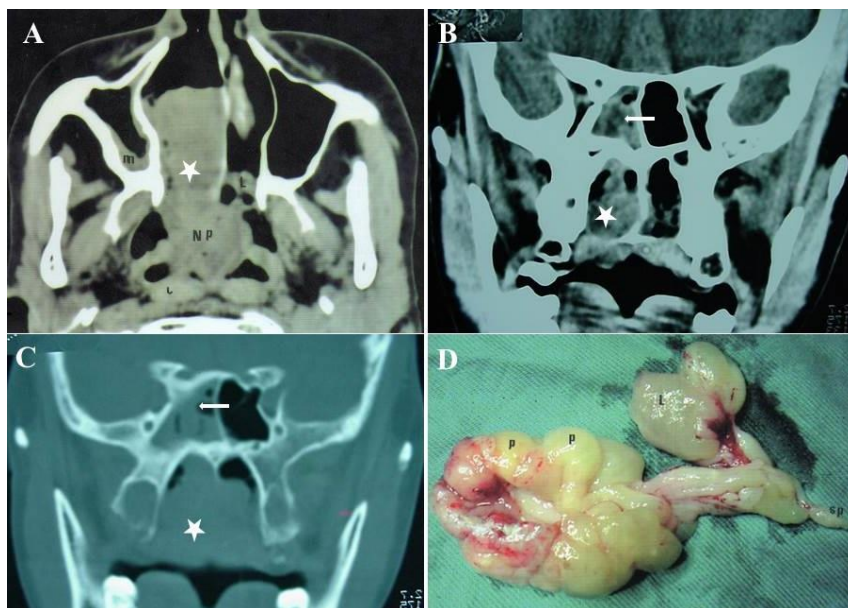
(A) CT scan with axial soft tissue window cut showing a soft tissue density mass filling most of the right nasal fossa (white asterisk), extending through the right choana into the nasopharynx (NP), then through the left choana into the posterior part of the left nasal fossa (L), with underdeveloped right maxillary sinus with concentric mucosal thickening (m). (B, C) CT scan with coronal soft tissue (B) and bone window (C) cuts showing a soft tissue density mass in the right sphenoid sinus (white arrows), filling the right choana (white asterisk in B) and nasopharynx (white asterisk in C). (D) A photograph demonstrating a freshly removed bi-lobed SCP with multiple polypoid projections on the surface (P), a narrow long pedicle of the polyp arising from the right sphenoid sinus (sp), and the part of the polyp that passed into the left nasal fossa (L in A and D).
